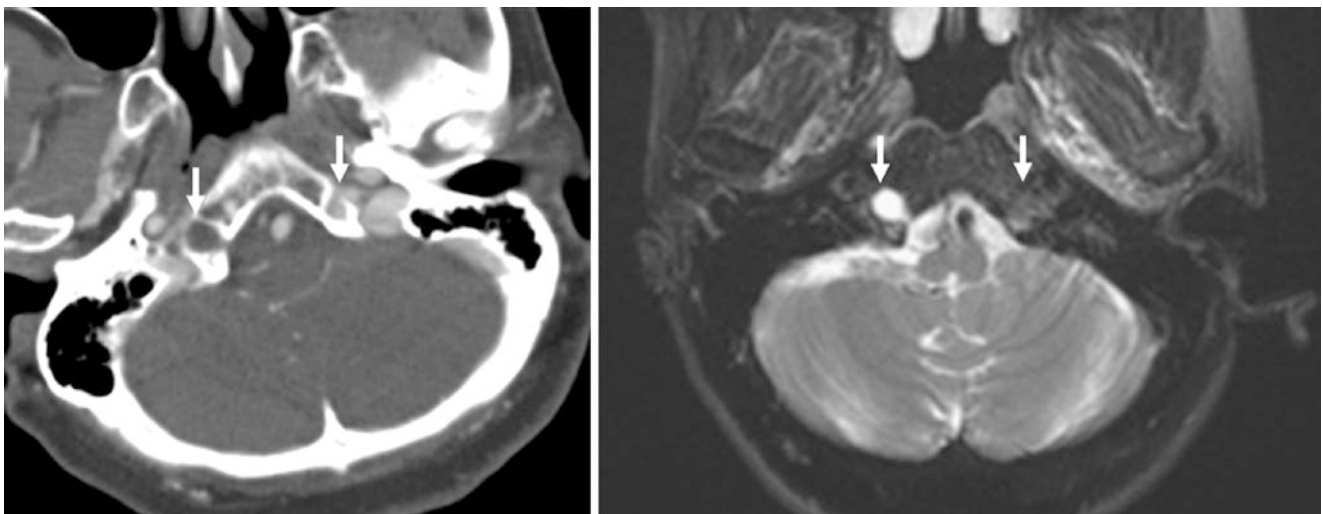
A 71 year old: regarding the hypoglossal canals (*arrows*), a CSF-filled right canal is noted on postcontrast CT (*left*) with bright signal within from the CSF on axial T2WI MRI (*right*). Note an enhancing venous plexus within the left hypoglossal canal and jugular foramen (*)
